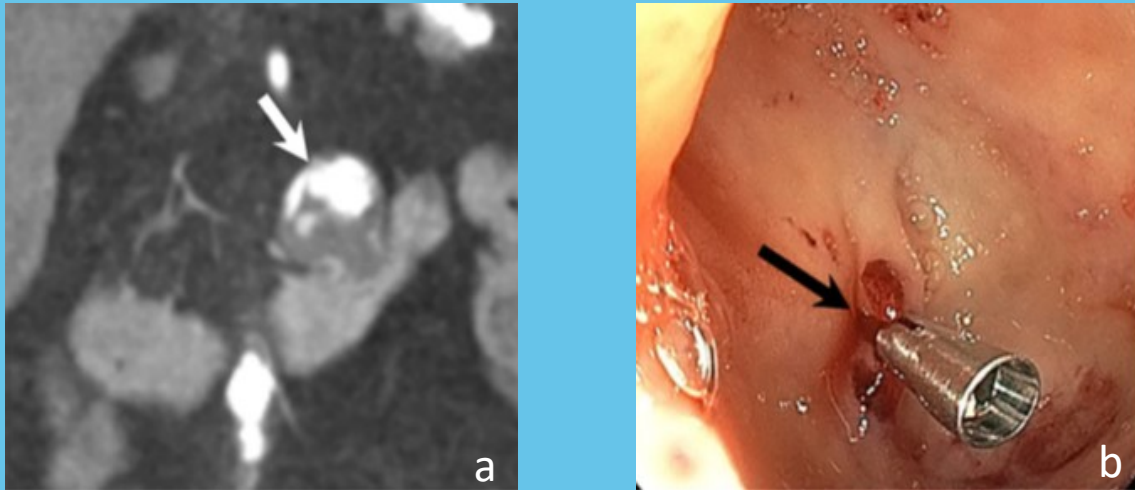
(a) CT angiogram performed on a patient with history of Crohn's disease in the setting of hemodynamic instability and hematemesis. CT imaging reveals active bleeding in a diverticulum of the duodenum. (b) Endoscopy was performed and the patient was treated with clip placement and epinephrine injection.
